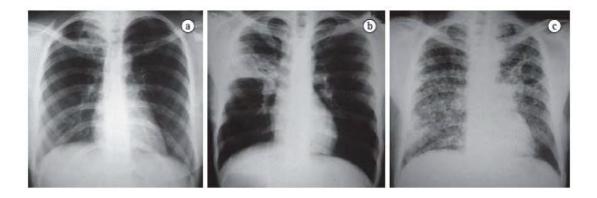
Chest X-rays of patients with pulmonary tuberculosis. In a) A 24-year-old male, weight loss in the last three months and current fever 38°C. In b) A 25-year-old female, dry cough for the last three months and recent worsening of health status. In c) A 38-year-old male, previously treated for tuberculosis for the last three weeks.
